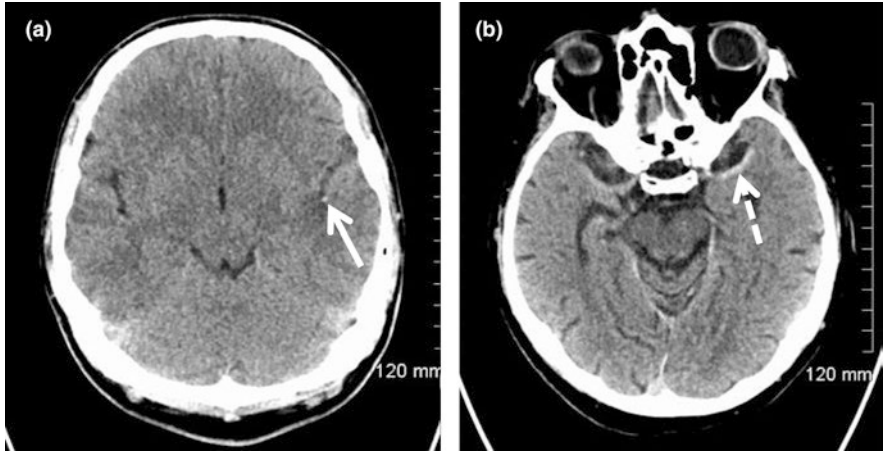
Non-contrast CT images in two different patients presenting with acute stroke. a Dot sign representing thrombus in a branch of the left MCA in the Sylvian fissure (solid arrow). b Hyperdense left MCA representing thrombus (dashed arrow). This was confirmed by performing a CT angiogram
